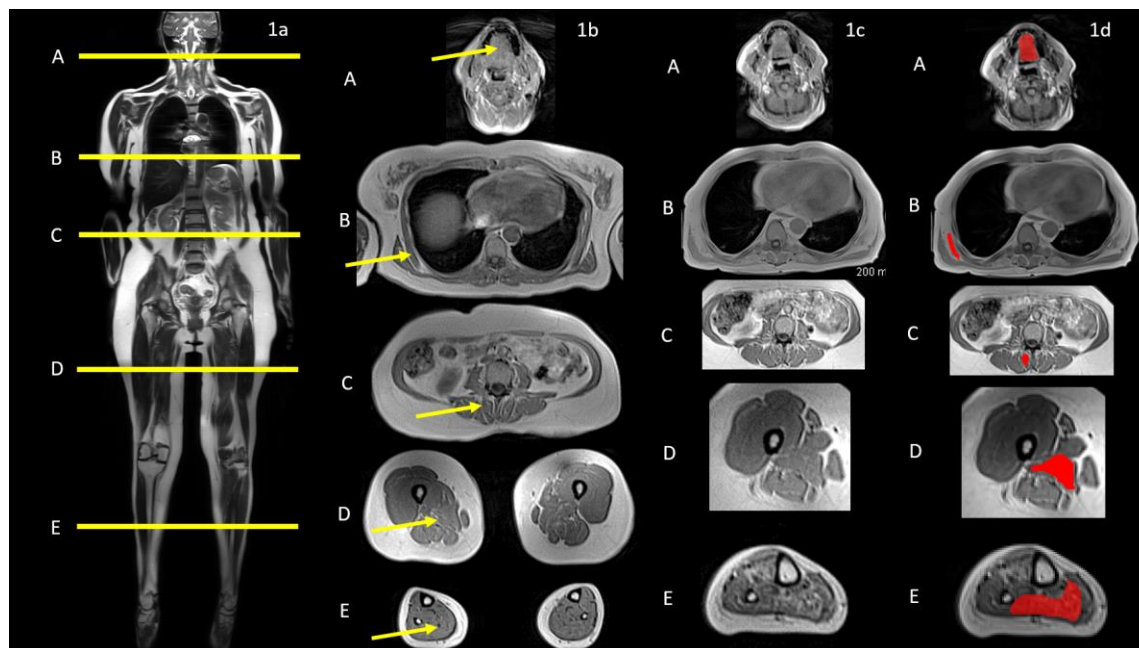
Muscle MRI in OPMD
